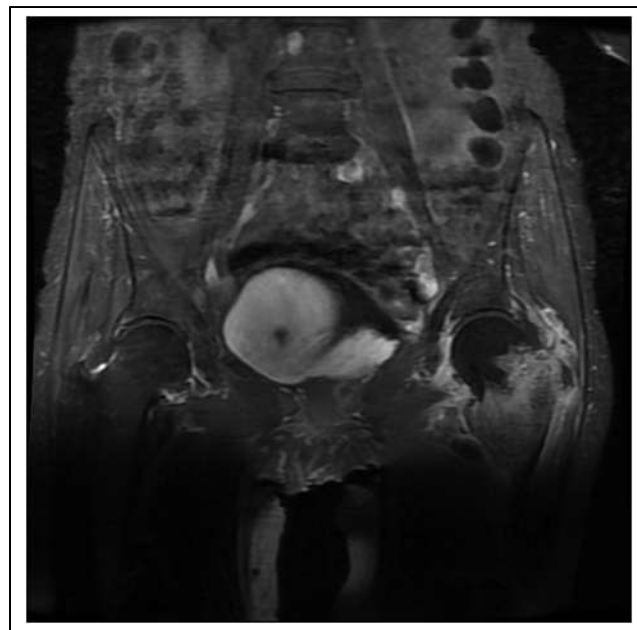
Coronal T1-weighted MR image through pelvis showing hypointense left femoral head.
